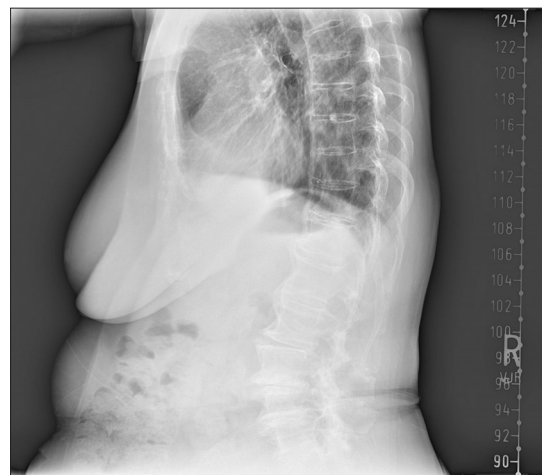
X-ray imaging of patient with AS and the pathognomic “bamboo spine.”
